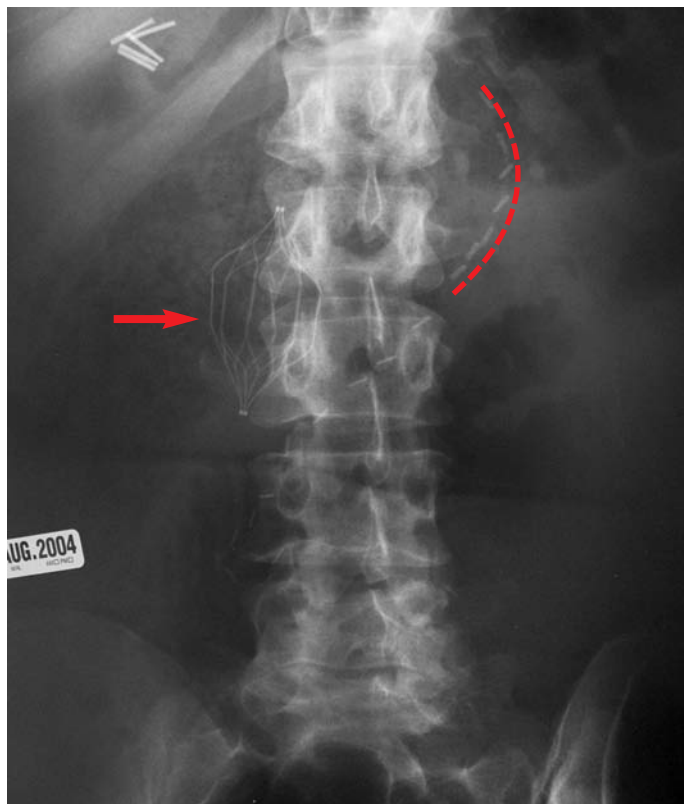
Sandra’s post-operative x-ray of her abdomen demonstrates the curved row of staples on her stomach (red dashed line), and the “umbrella” placed into her vena cava to prevent blood clots from reaching her heart (red arrow). Vascular clips are upper right. The metal umbrella was placed through her right groin, injuring a nerve.
